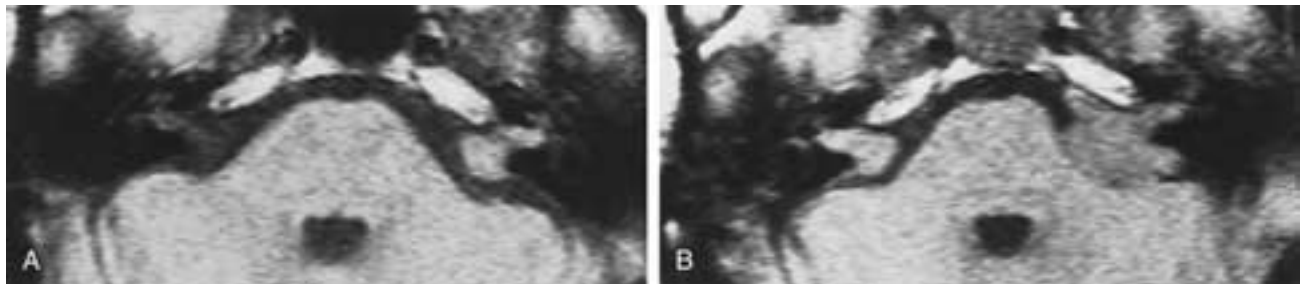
Metastases from carcinoma of the bladder. A and B, Postcontrast T1-weighted images obtained 1 month apart. The patient developed rapidly progressive hearing loss and facial palsy on the left side, followed by similar symptoms on the right.
